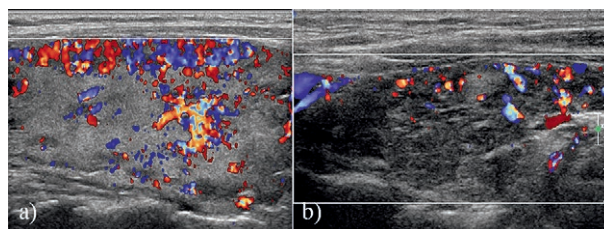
Vascularity in thyroiditis can be variable depending on the stage of the disease. a) Sagittal US image through the right lobe shows a heterogeneous gland with hypervascularity in it on color Doppler which is due to early stage in this patient. b) Different patient with known chronic thyroiditis shows a decreased vascularity likely due to the atrophic stage in this patient.
